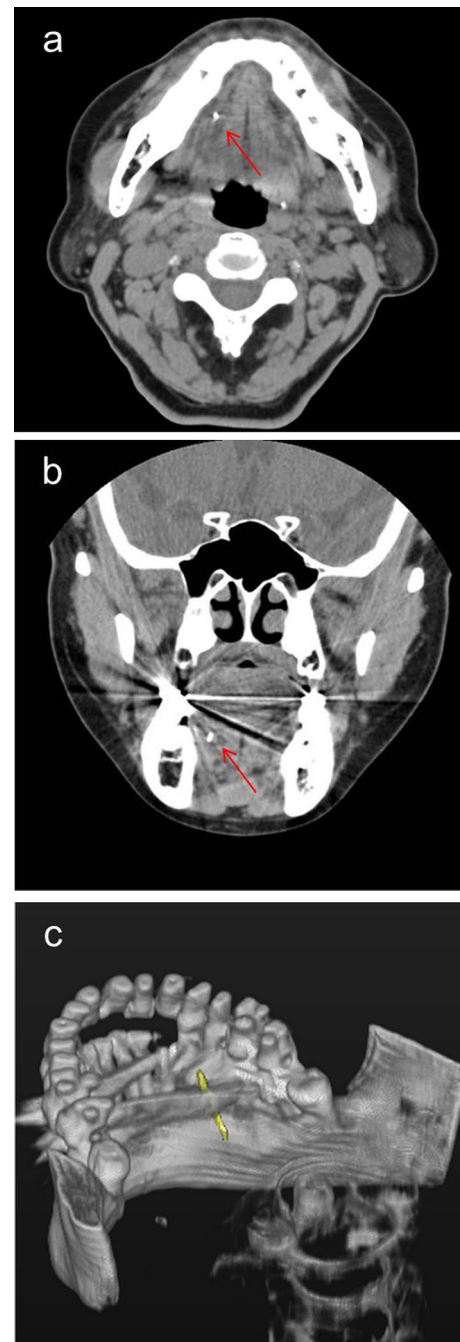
Preoperative computed tomography. a Axial view. b Coronal view. A round radiopaque foreign body was found in the right submandibular area. c Three-dimensional reconstruction using Simplant® dental planning software (Dentsply Sirona, York, PA, USA)
